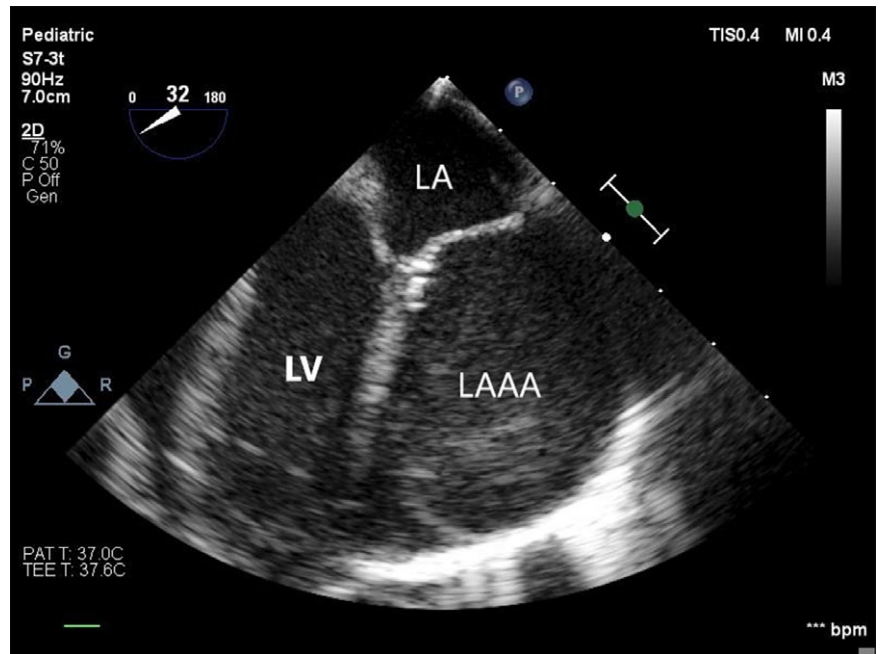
Transoesophageal echocardiogram showing a large left atrial appendage aneurysm overlaying and plateauing the left ventricle free wall (LAAA, left atrial appendage aneurysm; LA, left atrium; LV, left ventricle).
